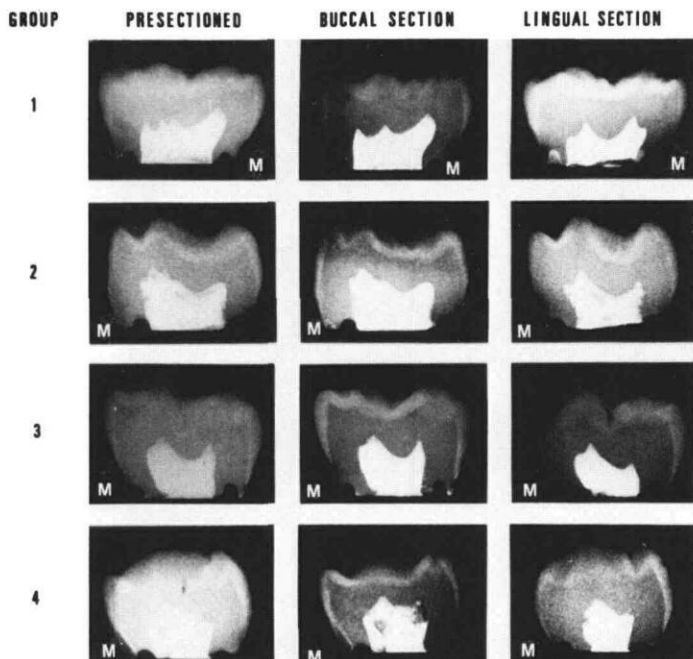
Radiographs of presectioned, buccal, and lingual sections of each of the four primary molar types. Note the overlapping of the cuspal outlines of the buccal and lingual sections on the presectioned films (M — Mesial).
